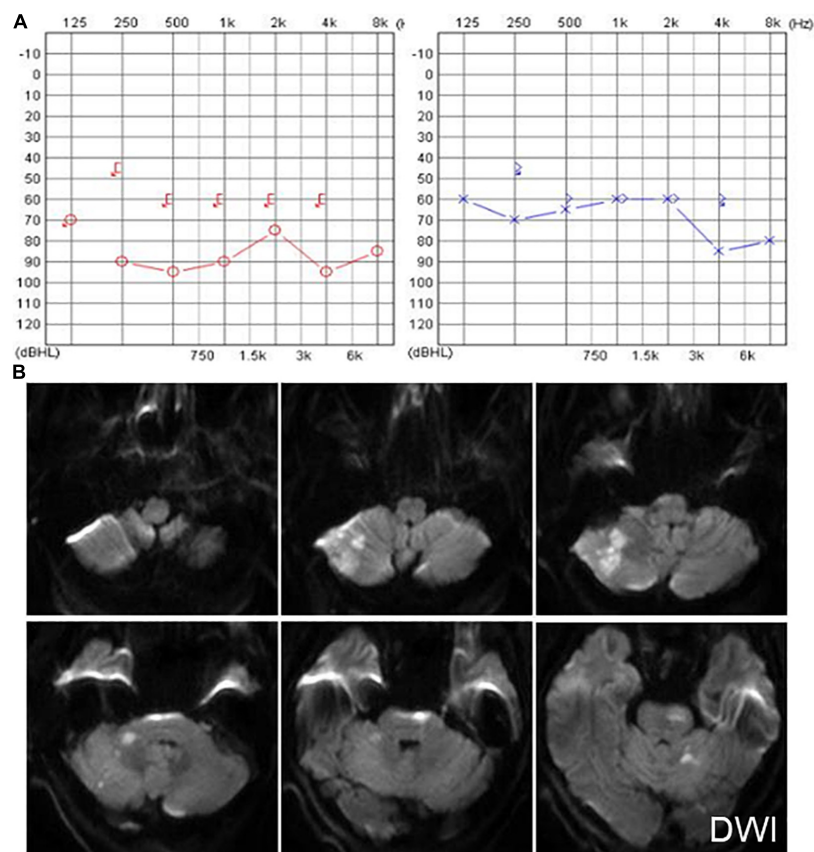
The PTA and MRI of the patient with extensive infarction of the brainstem and cerebellum. (A) PTA shows a bilateral sensorineural hearing loss in a patient with extensive infarction of the brainstem and cerebellum. (B) Brain MRI shows lacunar foci in the bilateral basal ganglia.
